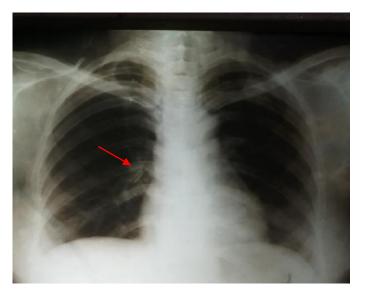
Radiograph showing endodontic file in right bronchus
